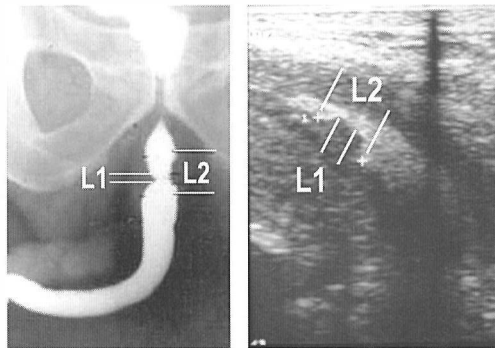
Radiographic and sonographic appearance of the same stricture. (Different degree of photographic magnification - direct length comparison is impossible). L1-the length of a tight stricture, L2-the whole length of the stricture.
